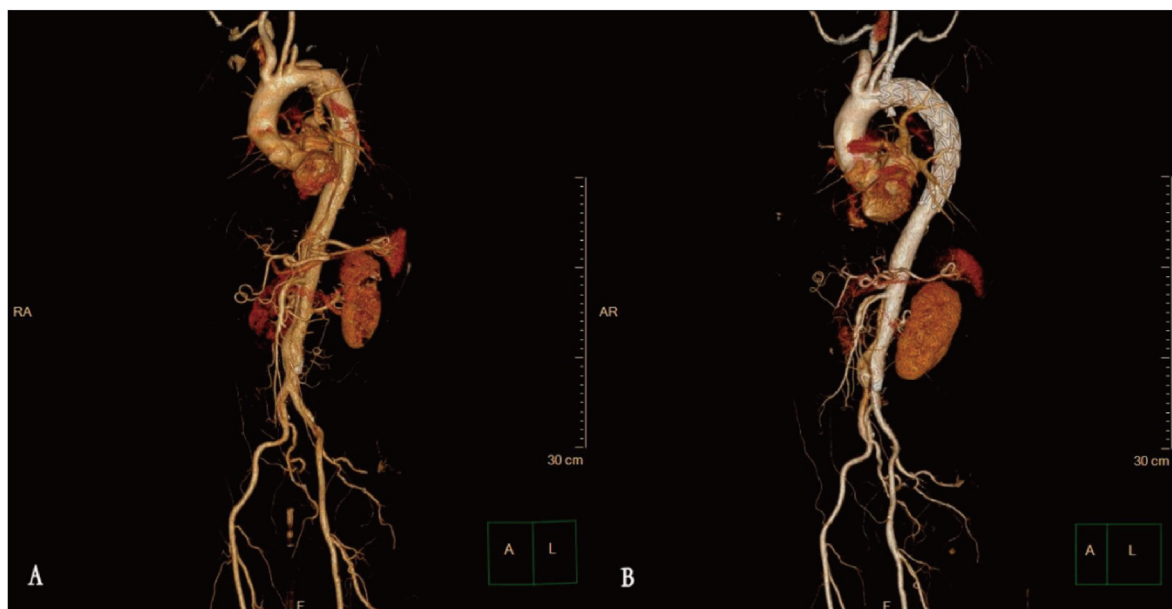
Preoperative and postoperative CTA and 3D reconstruction of the aorta and branch vessels.
